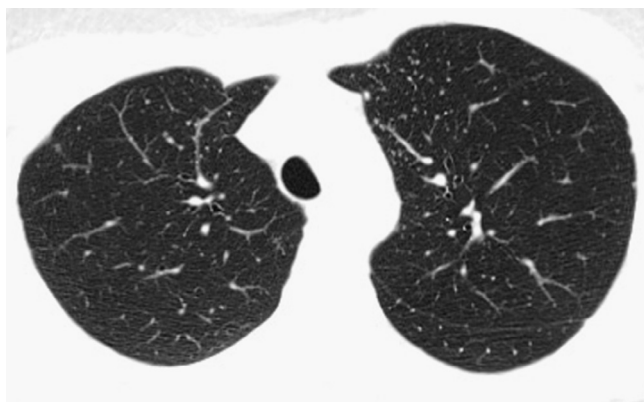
Metastatic thyroid cancer. Computed tomography scan of a patient showing metastatic thyroid cancer with micrometastases. (Courtesy Michael B. Gotway, MD.)
